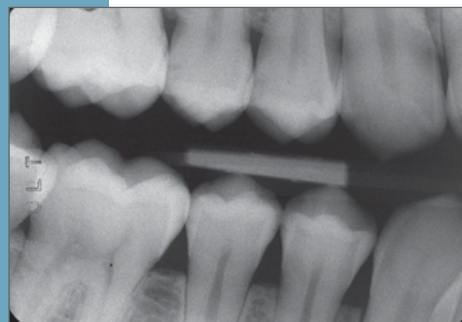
(left) Initial bitewing revealing a proximal caries lesion in the maxillary first and second premolars.
